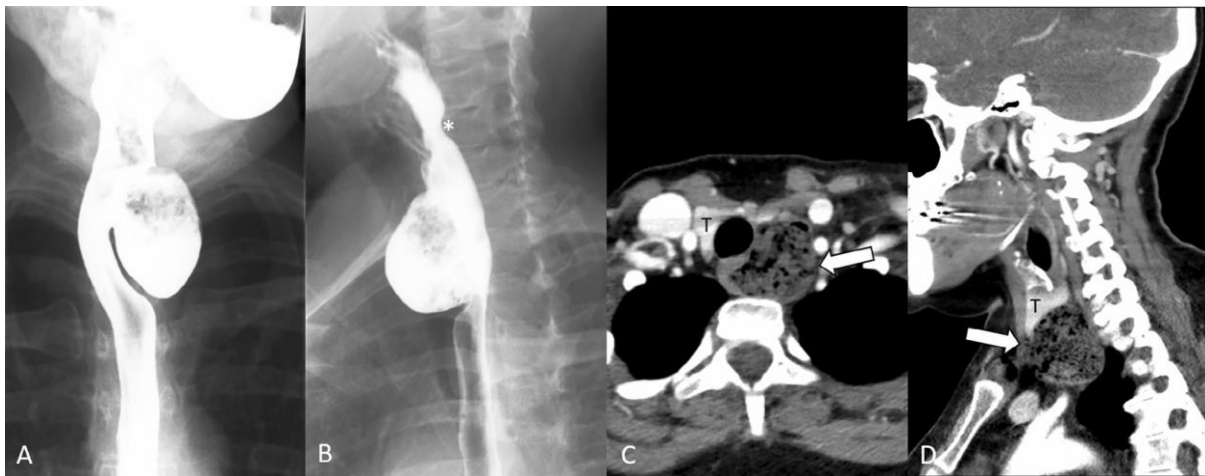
A 57-year-old female with imaging characteristics of Killian–Jamieson diverticulum (KJD). (A) Anteroposterior (AP) esophagogram shows a lateral hypopharyngeal diverticulum. (B) Lateral esophagogram demonstrates the diverticulum arising anterolaterally from the esophagus, just below the cricopharyngeal muscle (*). (C) Axial CT image showing the diverticulum (white arrow) arising from the left esophagus, immediately inferior to the thyroid gland (T), containing retained food material. (D) Sagittal CT image again demonstrating the diverticulum (white arrow) located just below the thyroid gland (T).⁵
